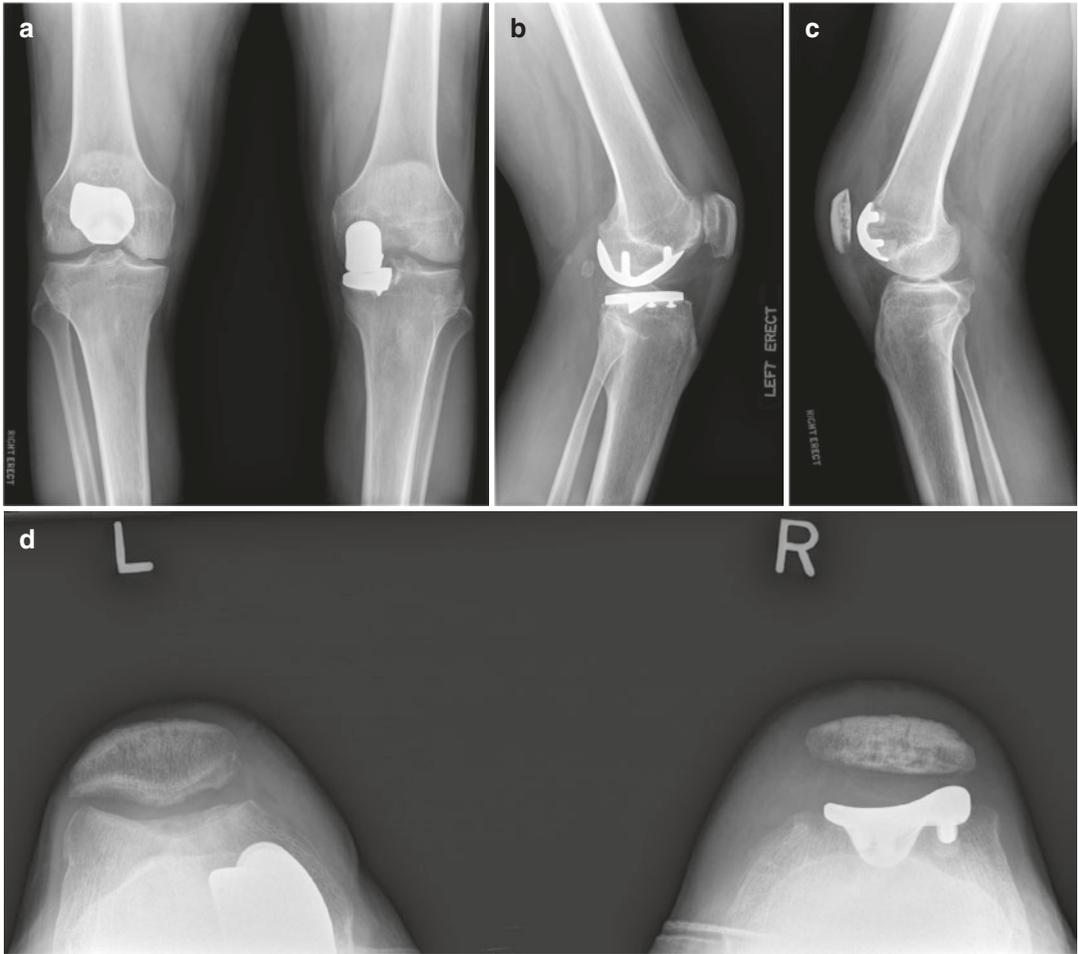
Postoperative anteroposterior, lateral radiographs, merchant views of patellofemoral arthroplasty, and unicompartmental arthroplasty
